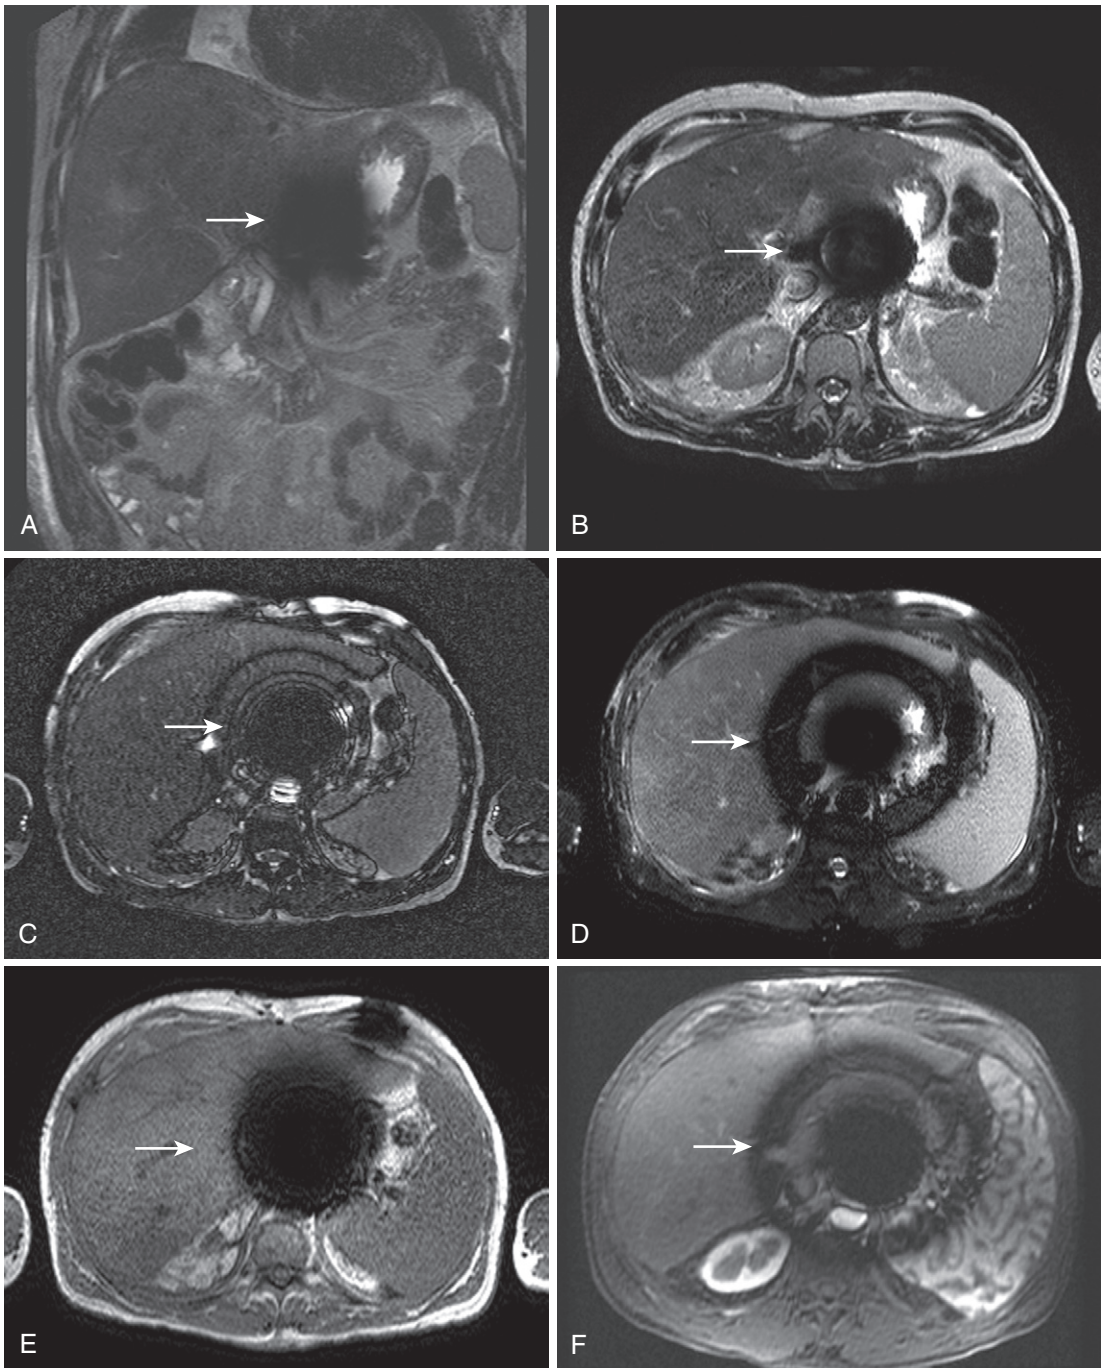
SSFSE images minimizing susceptibility artifact. Coronal (A) and axial (B) T2-weighted SSFSE images in a patient with embolization coils in gastrohepatic collaterals corresponding to susceptibility artifact (*arrow* in A-F) in the epigastric region, which is minimized compared with the axial steady-state image (C)—an alternative localizer—the fat-suppressed T2-weighted fast spin-echo (FSE; D), the in-phase (E) and the fat-suppressed arterial phase (F) gradient-echo images. Note the clear depiction of loops of small and large bowel on the coronal SSFSE image.
